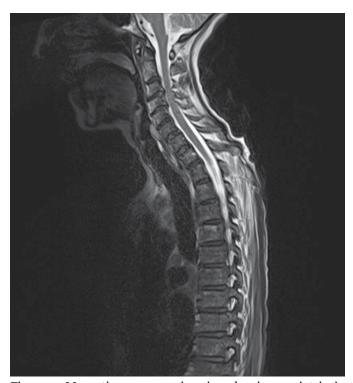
Magnetic resonance imaging showing no intrinsic cervical/thoracic cord abnormality. There are, however, spondylotic changes in the mid-cervical spine resulting in spinal canal narrowing – although not deemed to be extensive enough to cause the symptoms discussed. There is also a small central disc protrusion at  $T_5/6$ .
